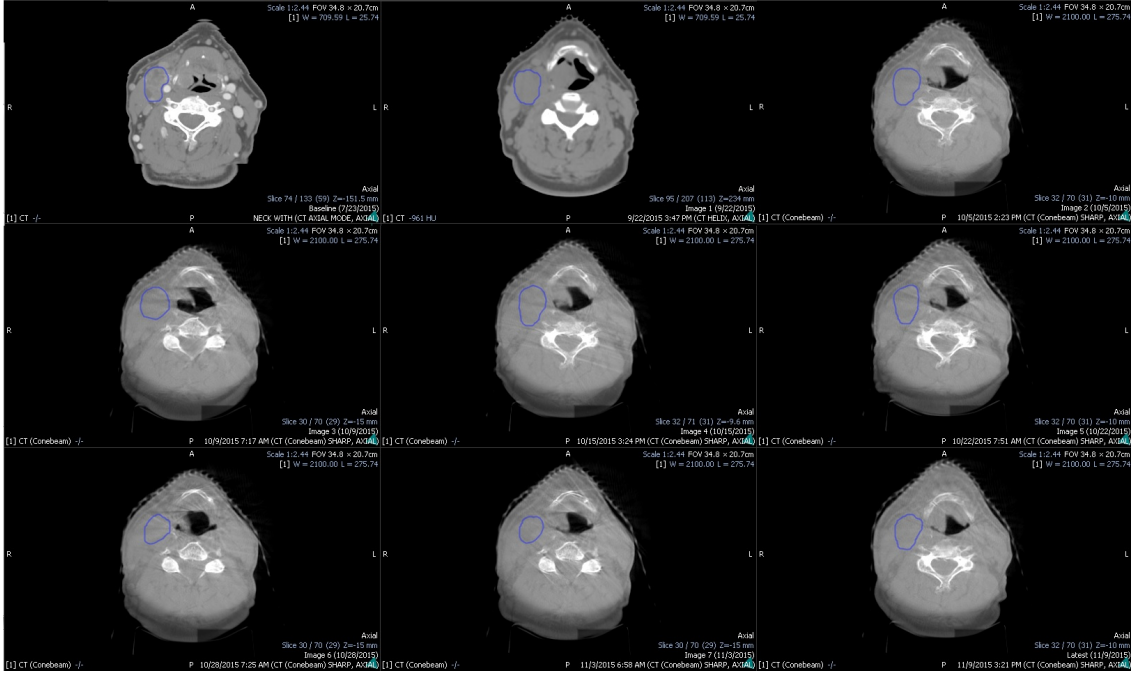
Example of a CT scan of a single oropharyngeal cancer patient across multiple time points; tumour contoured in blue. (data courtesy of CD Fuller and MD Anderson)
